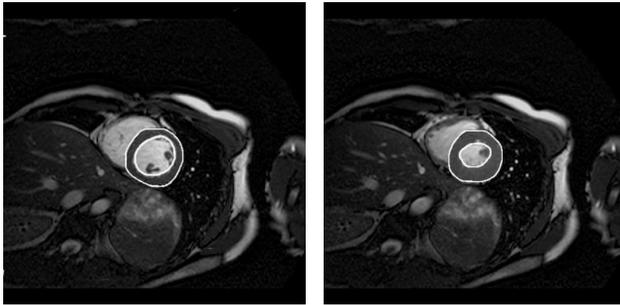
Segmented MRI short axis views during diastole (left) and systole (right). The left ventricle contours are marked. Image sizes are 378×378 mm.
